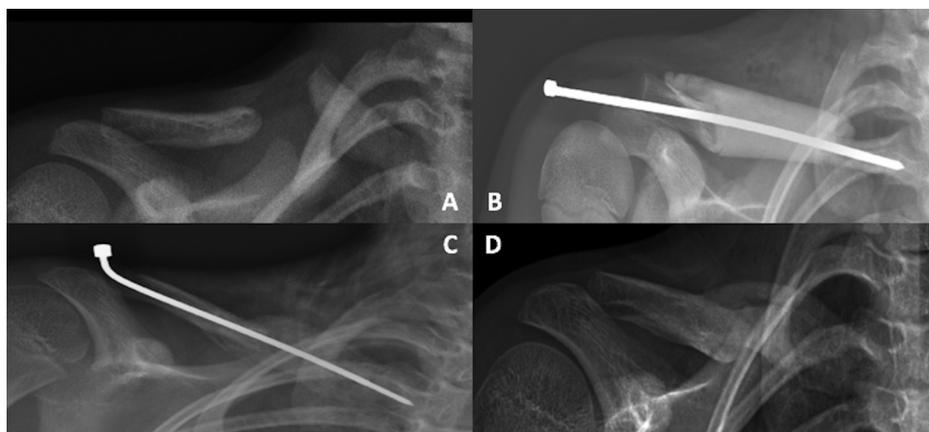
Patient #4, clavicular reconstruction for congenital pseudarthrosis of the right clavicle. A. Pre-operative radiograph. B. Radiograph taken immediately after the first stage of the induced membrane procedure. C. Radiograph taken immediately after the second stage of the induced membrane procedure. D. Radiograph taken at last follow-up after 1 year.
